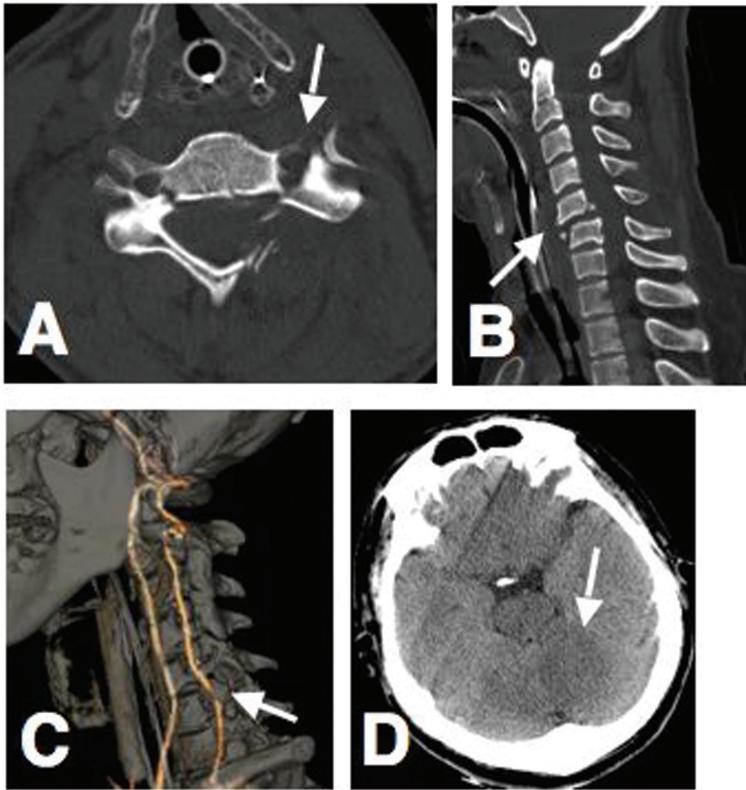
Several imaging studies in a 41-year-old male (case 8). A: Cervical spinal computed tomography (CT) axial scan showing significant facet fractures extending into the foramen transversarium (*arrow*). B: Cervical spinal CT sagittal scan showing a significant subluxation at the level of C5/6 (*arrow*). C: Three dimensional (3D)-CT angiogram demonstrating an abrupt discontinuance of left vertebral artery (*arrow*) at the site of the fracture. D: Brain CT axial scan demonstrating a cerebral infarction in left cerebellar hemisphere (*arrow*).
